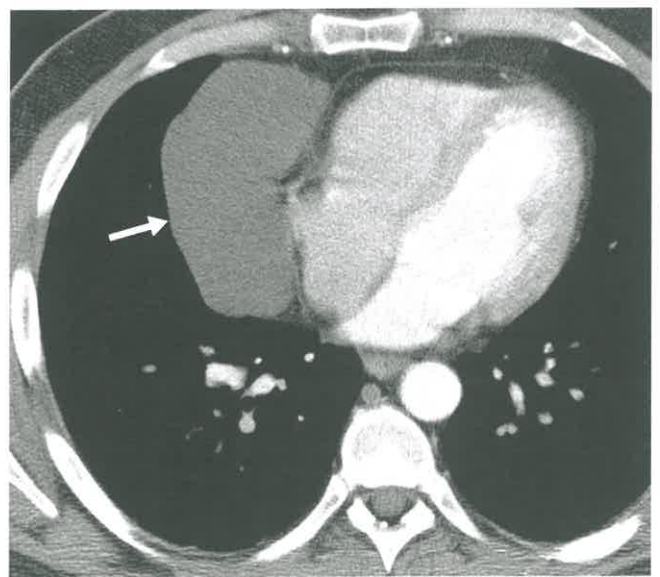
Pericardial Cyst. Enhanced CT scan through heart shows a smooth, sharply marginated, low-attenuation mass (arrow) in the right cardiophrenic angle, consistent with a pericardial cyst.
